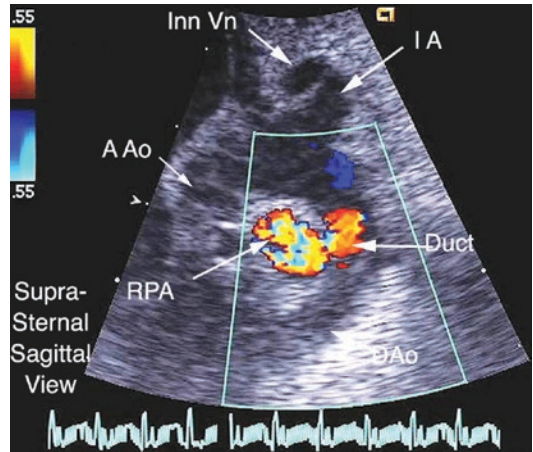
This suprasternal sagittal plane cut in the plane of the aortic arch in an infant shows the presence of a patent arterial duct (Duct) shunting left to right on this Doppler color flow image. The flow disturbance carries out into the right pulmonary artery (RPA). Other abbreviations: *AAo* ascending aorta, *Inn Vn* innominate vein, *IA* innominate artery, *DAo* descending aorta
